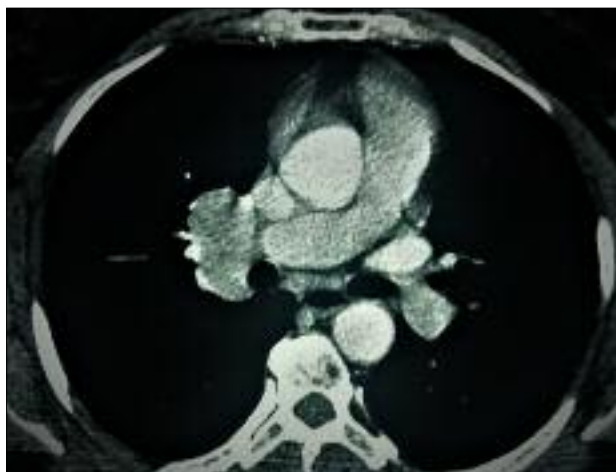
Chest computed tomography revealed a well-defined and homogenous enhanced mass in the right hilum.
